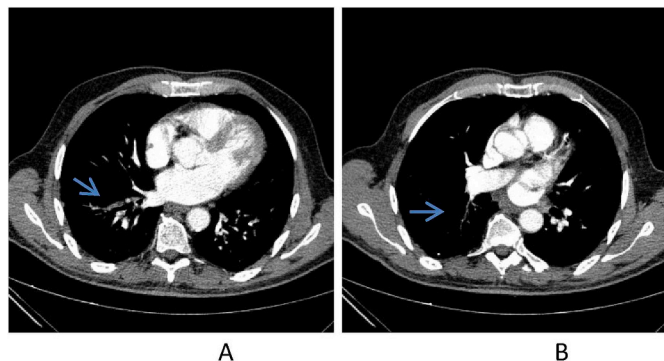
74-year-old man with 6 months of persistent dry cough and hypothyroidism. CT pulmonary angiography shows pulmonary emboli with abrupt caliber change in right lower lobe artery (arrow in A and B).
